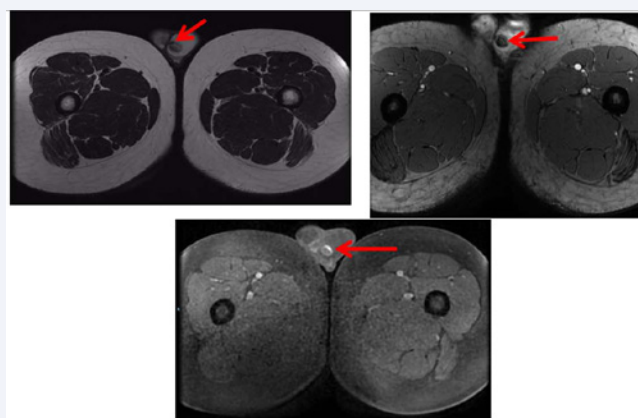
A 24-year-old man with left-sided haematoma, correctly localized and characterized with MR. Coronal T2-weighted (left), GRE sequence (center), and T1-weighted fat-suppressed (right).
